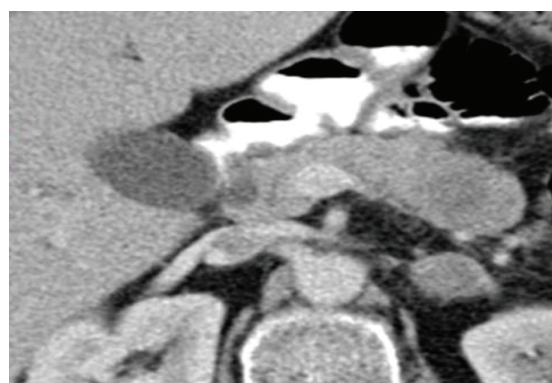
CT images-Metastases
